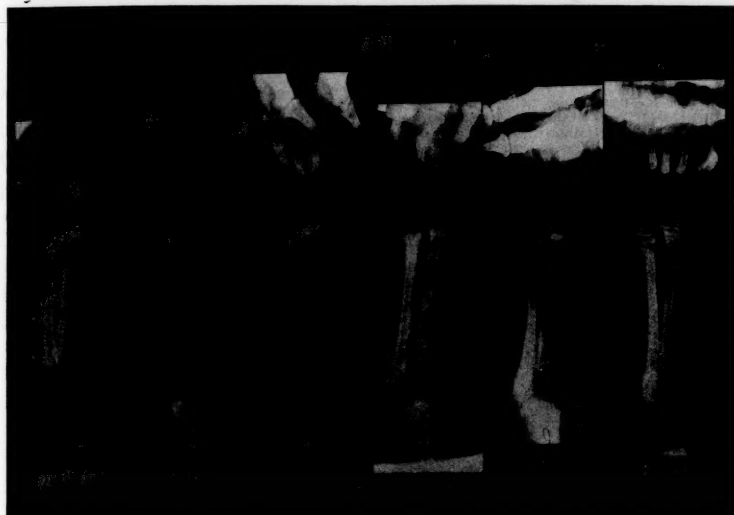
Case No. 1. L. H. Female aged 10½ months treated with the sun's rays through quartz window panes. Roentgenograms show progressive increase in the density of the epiphyses and shafts of the bones.
